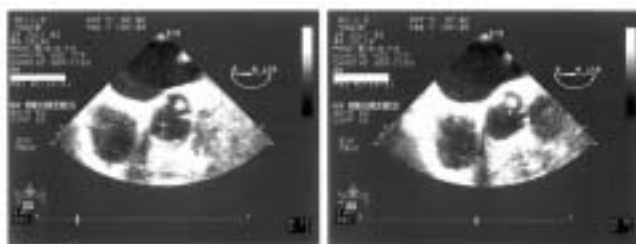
Transesophageal echocardiogram showing the papillary fibroelastoma.
